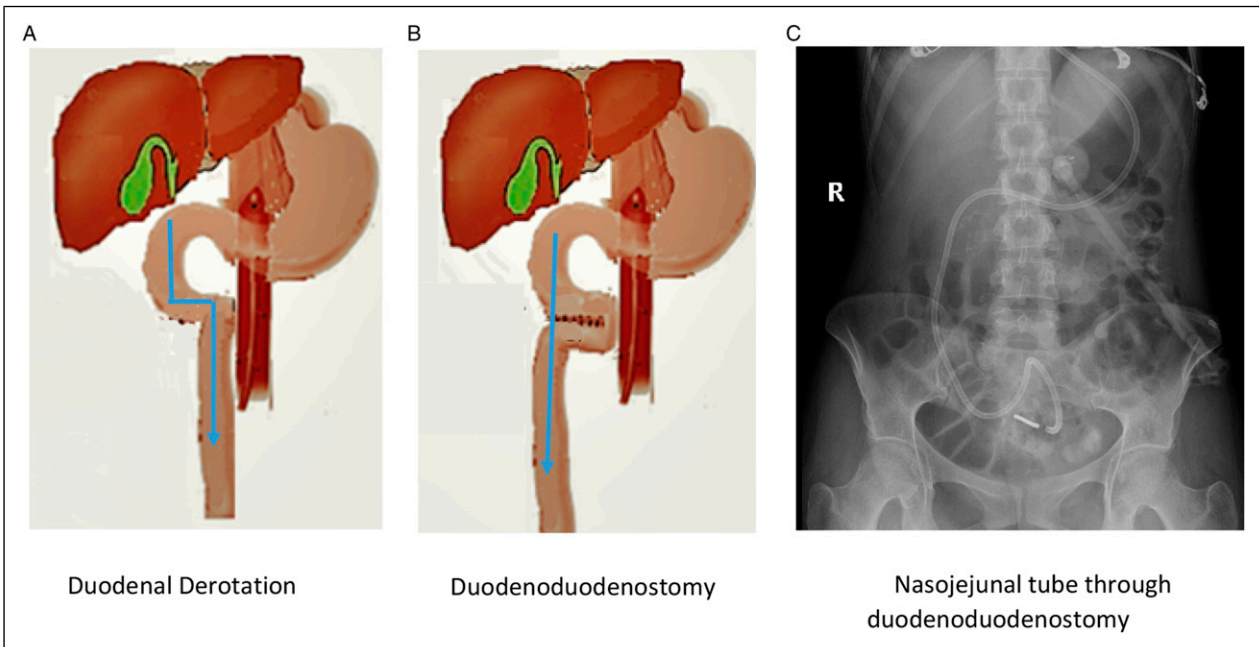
Transit through the duodenum. (A). Duodenal derotation - Pathway through duodenal derotation procedure. (B). Duodenoduodenostomy - Pathway through duodenoduodenostomy. (C). Nasojejunal tube through duodenoduodenostomy - Patient's abdominal X-ray with nasojejunostomy feeding tube through duodenoduodenostomy.
